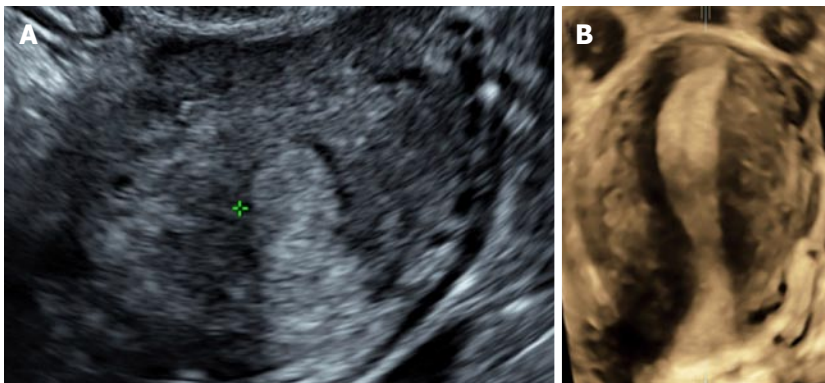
Unicornuate uterus with no rudimentary horn. A: Transverse 2D ultrasound image shows a single endometrial cavity; B: Coronal 3D (with VCI) ultrasound image of the unicornuate uterus showing a single uterine horn with no divergence of the endometrium towards both ostia and absence of a rudimentary horn. 3D: Three-dimensional; 2D: Two-dimensional; VCI: Volume contrast imaging.
